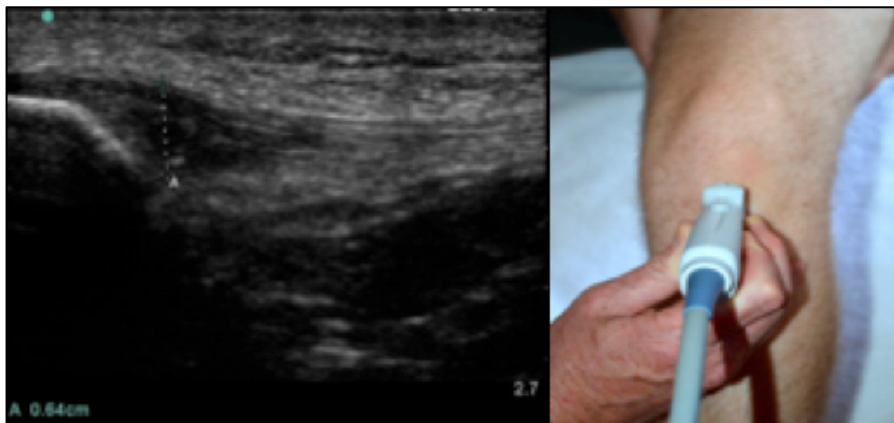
Orientation of the ultrasound transducer to visualise the tendon in the longitudinal plane
